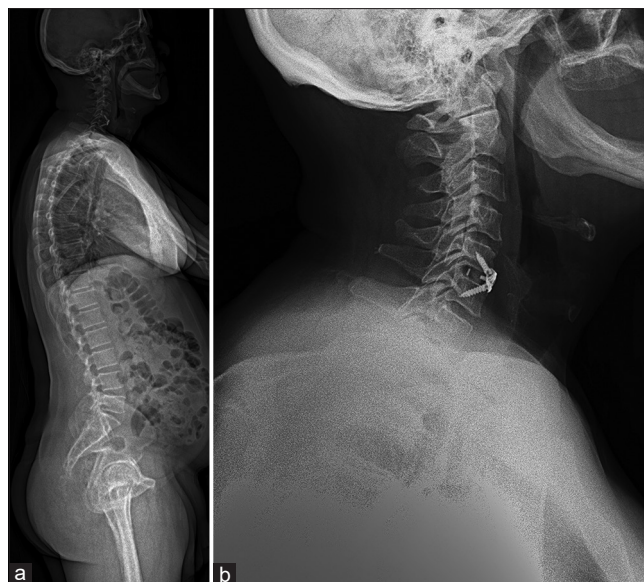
Postoperative images of patient with Perfect-C cage. (a) Standing lateral EOS. (b) Lateral cervical X-ray
